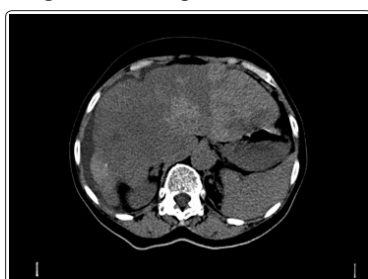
Axial CT scan of a heteromultinodular hepatic tumor
